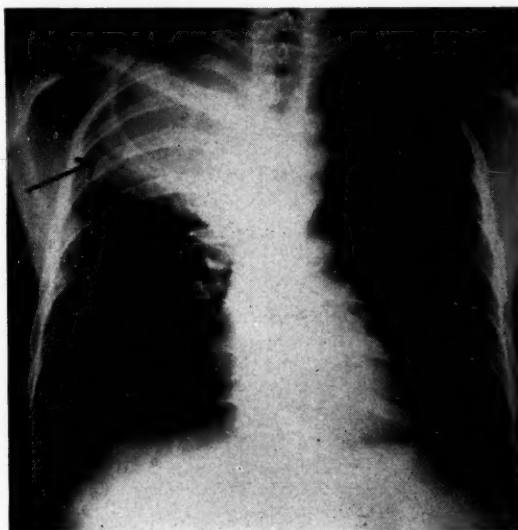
Roentgenogram of lungs on arrival. Tumor easily discernible in upper right lobe.
